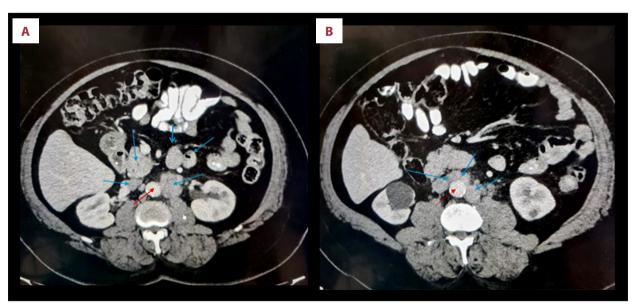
(A, B) Computed tomography scan section depicting the retroperitoneal adenopathy as shown by blue arrow; the red arrow marks the aorta.
